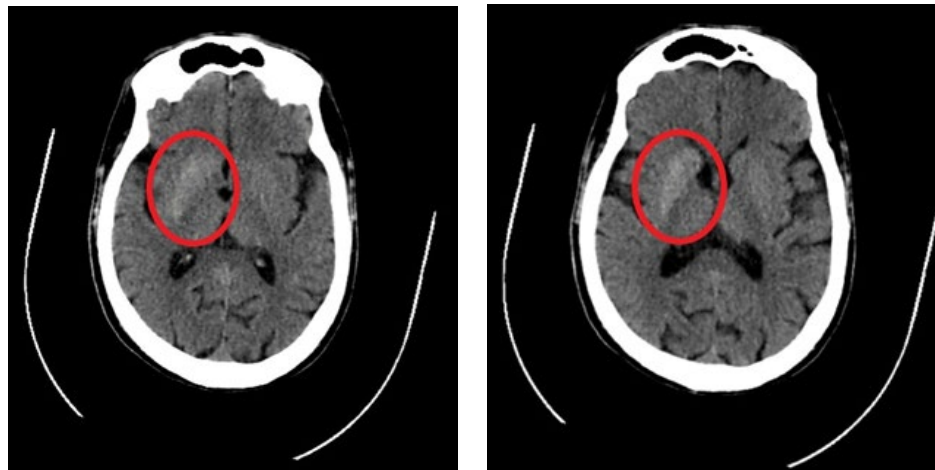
Plain Cranial CT scan of the patient showing asymmetrically hyperdense caudate nuclei and lentiform nuclei, appearing more hyperdense on the right, suggestive of systemic metabolic abnormalities such as non-ketotic hyperglycemia.
